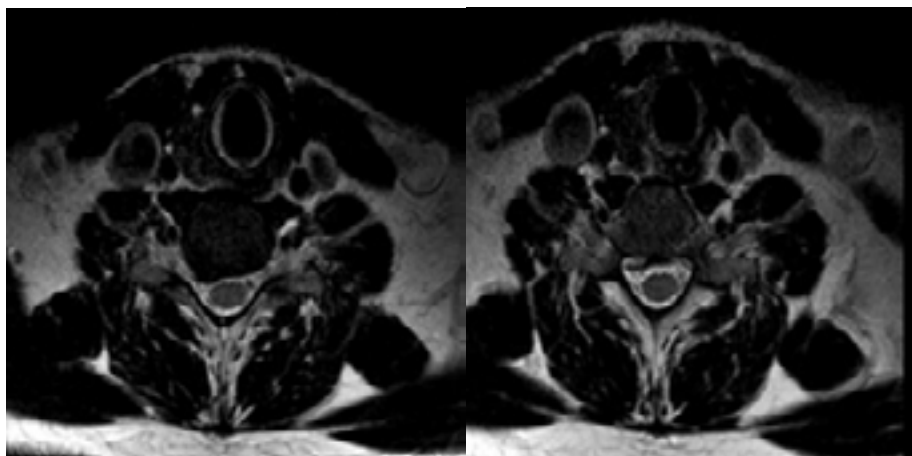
MRI of the cervical spine after one year shows a slight interval size reduction of previously identified large right paracentral disc extrusion at C6-7. Persistent right paracentral large disc osteophytic complex of the exiting right neural foramen.
